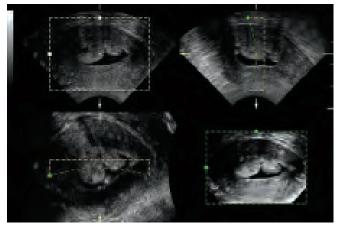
Three-dimensional saline infusion sonography in an infertile patient with two endometrial polyps
